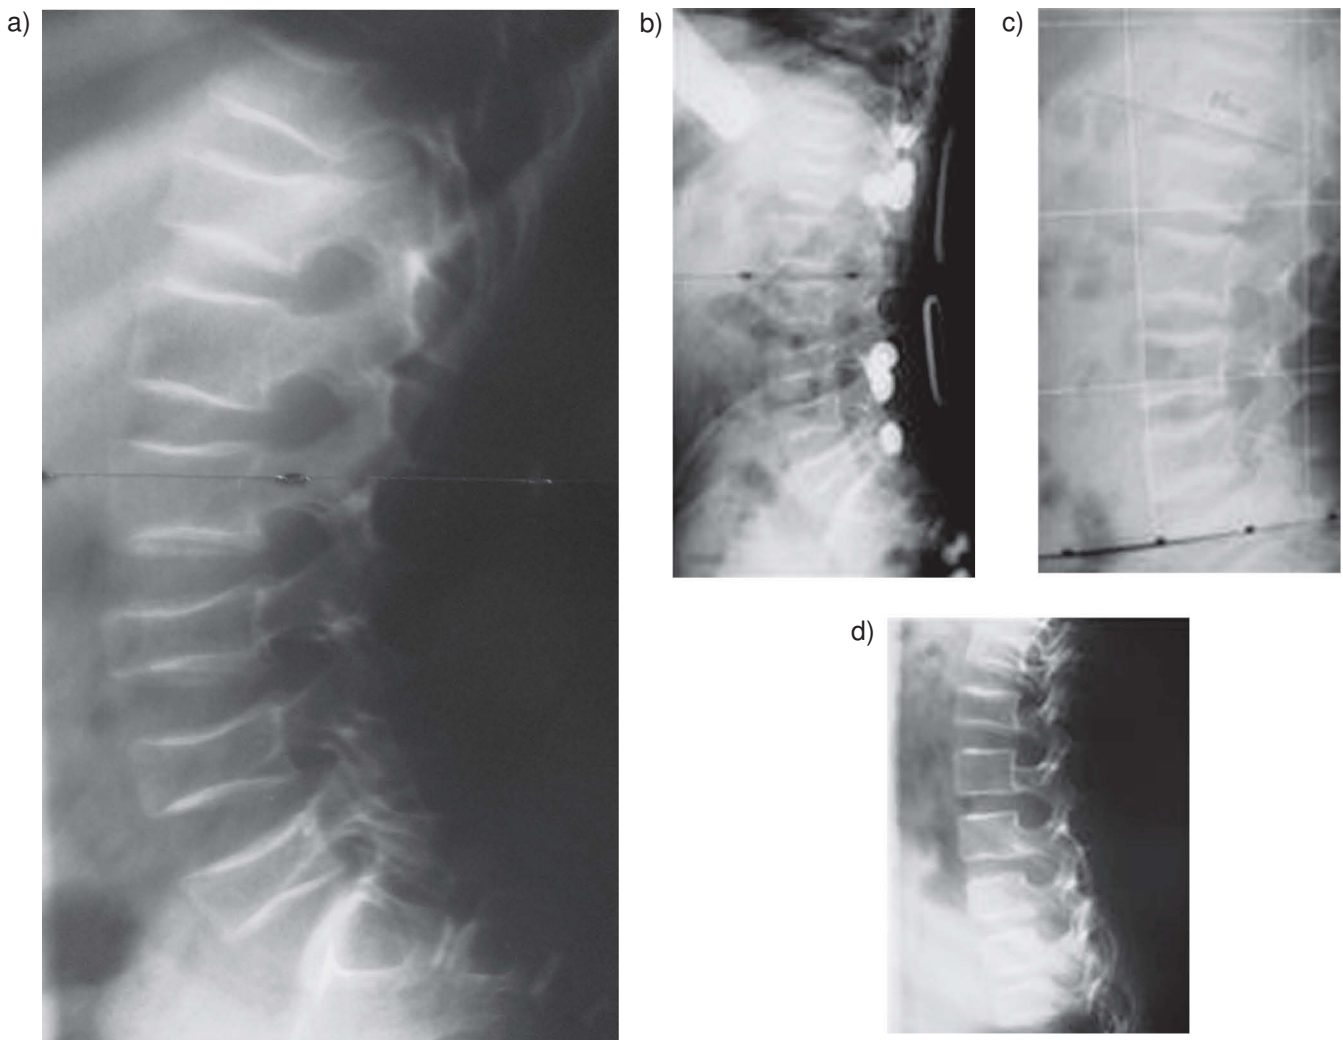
X-ray Images of the lumbar spine of a girl with osteogenesis imperfecta and multiple vertebral wedgings. Recovery of vertebral body morphology and height is noted following bisphosphonate therapy.
